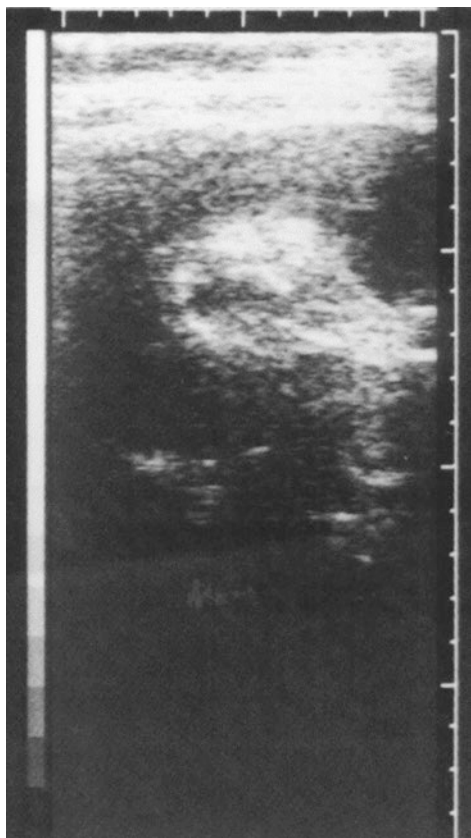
The irrigating fluid infiltrates into the muscle wall, presenting cloudy strong echo under ultrasonography
